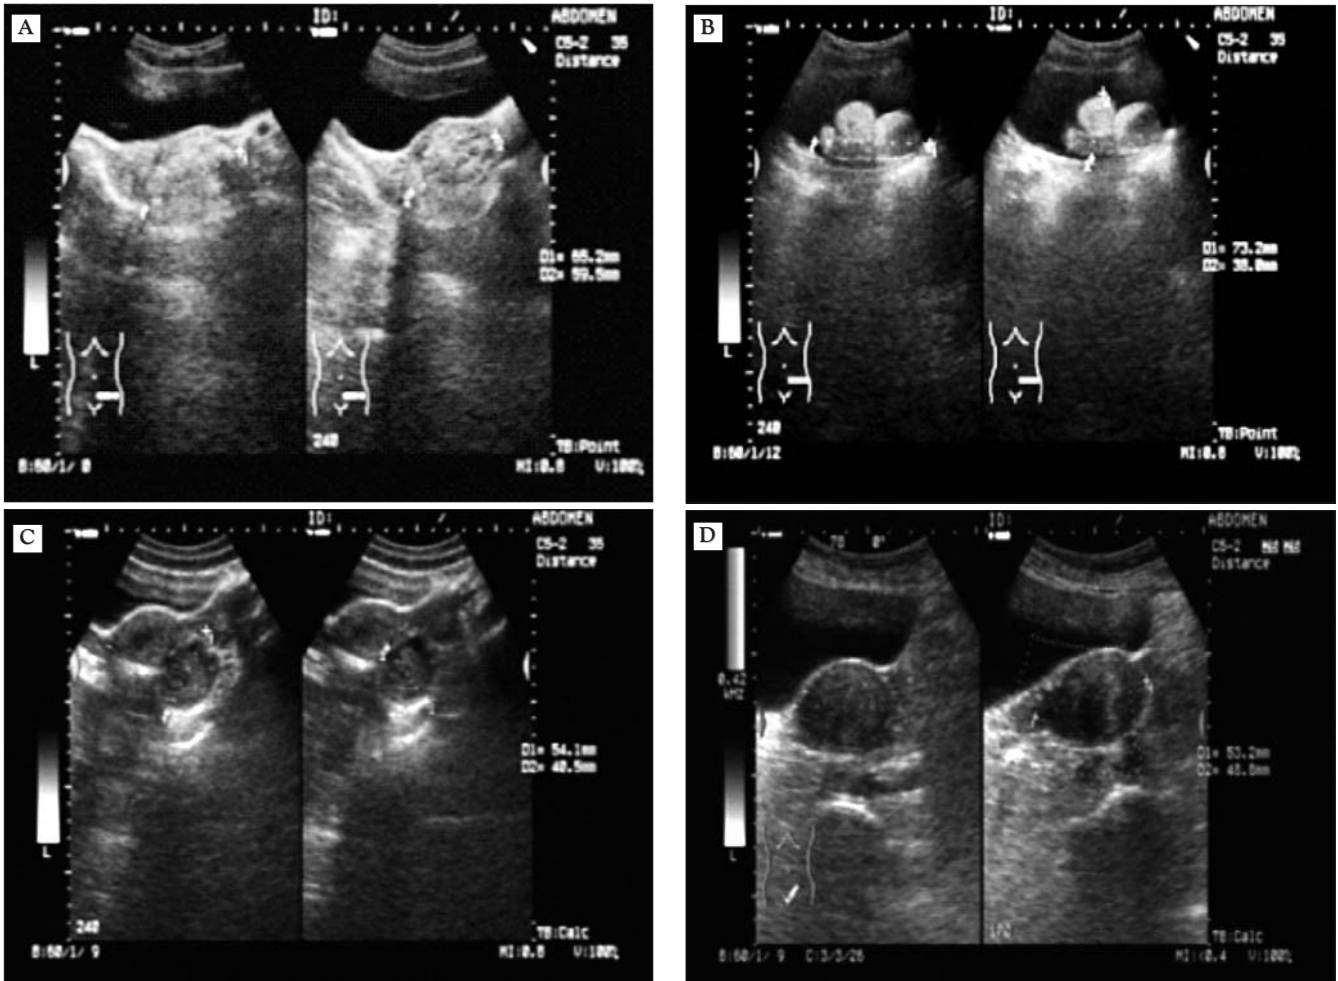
Ultrasound aspects of ovarian dermoid cyst. (A) Left ovarian mass intense echogenic, homogenous, well circumscribed by 55/59 mm with posterior acoustic attenuation; (B) In hypogastrium and left, fluid mass containing inhomogeneous image by 73/38 mm with posterior acoustic shadow. (C,D) Left ovarian cystic mass well circumscribed, without Doppler signal, with multiple floating balls.*
